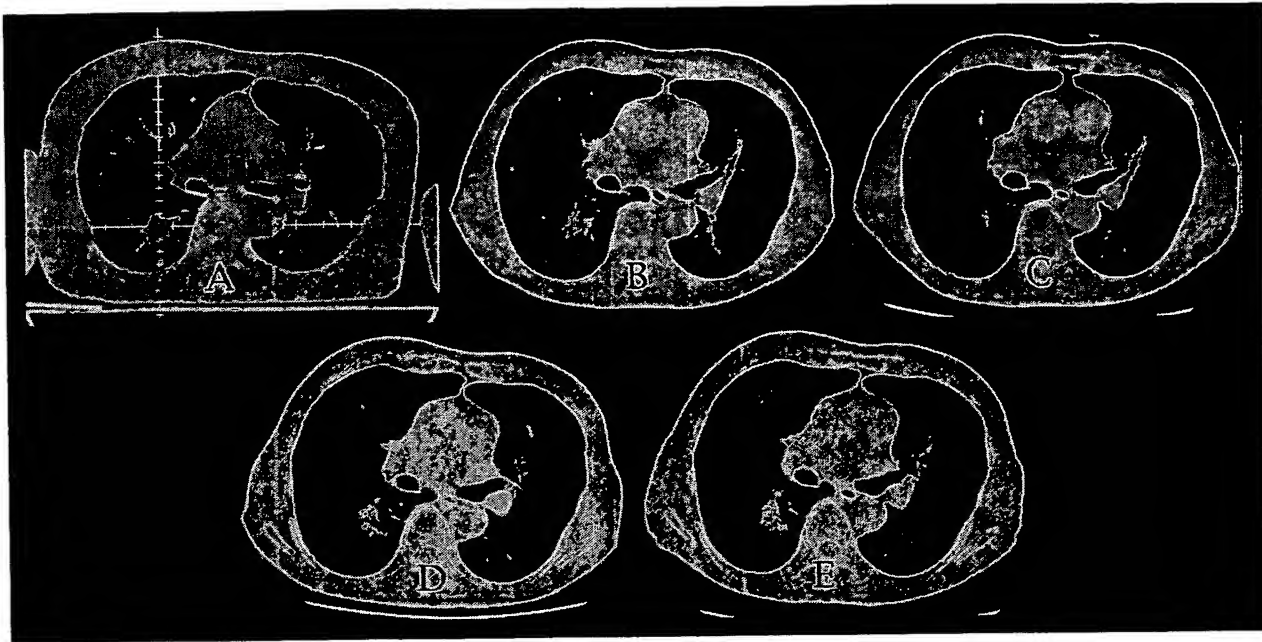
T1N0 M0 adenocarcinoma of the lung. (A) A 2.5-cm tumor is seen in the center image of the positioning CT scan on the treatment day. This CT image was scanned slowly (4 s/scan) with shallow respiration. SRT of 50 Gy in 5 fractions during 1 week was given at the 80% isodose line of 3.5 cm in diameter. (B) Two months after SRT, the tumor had shrunk. (C) Fifteen months after SRT, the tumor disappeared. (D) Thirty-three months after SRT, a limited volume of radiation fibrosis was seen. (E) Forty-three months after SRT, the volume of the fibrosis looked somewhat smaller.
